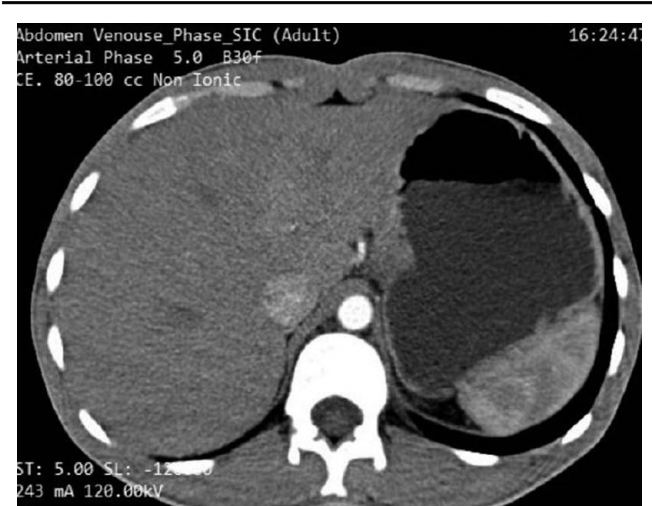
Computed tomography scan demonstrated a mild gastric dilatation.
